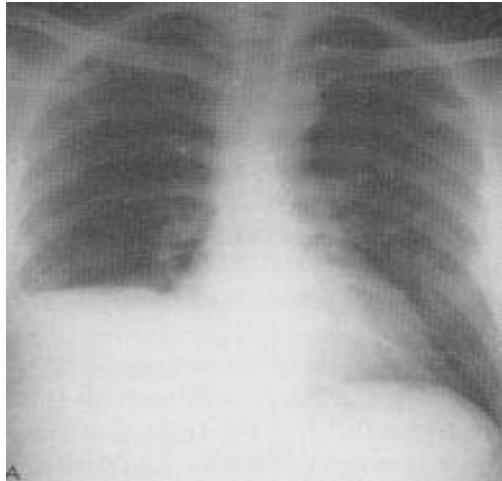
Plain Chest radiograph demonstrates an elevated right hemi diaphragm & Rt pleural effusion in a patient with an amoebic liver abscess.
